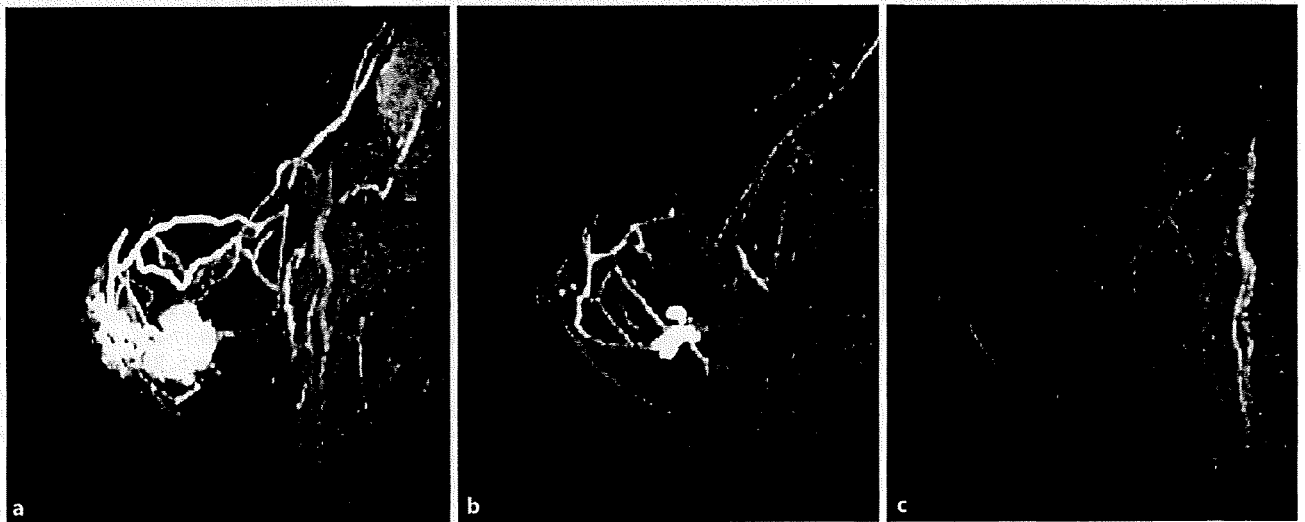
Contrast-enhanced MRI images in a 60-year-old woman with $\geq 80\%$ of tumor shrinkage after paclitaxel. a Before paclitaxel. b Reduction rate was 80% after paclitaxel. c The final reduction rate was 100% after the completion of paclitaxel followed by FEC. Her tumor attained pCR.
